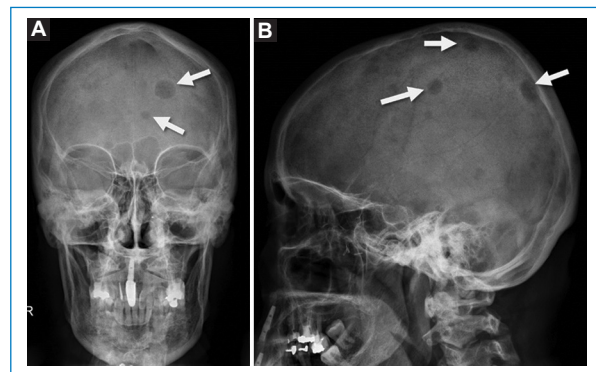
Anteroposterior (A) and lateral (B) skull radiographs demonstrating osteolytic lesions (arrows) with "punch-out" morphology.
